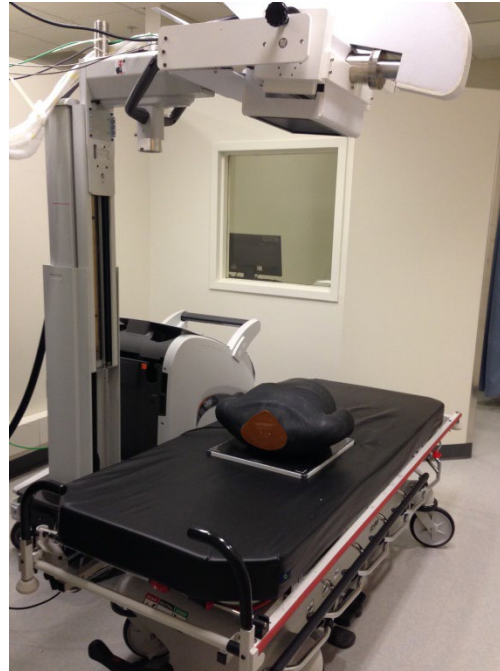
A photograph of the stationary digital chest tomosynthesis imaging system with a CNT x-ray source array.
